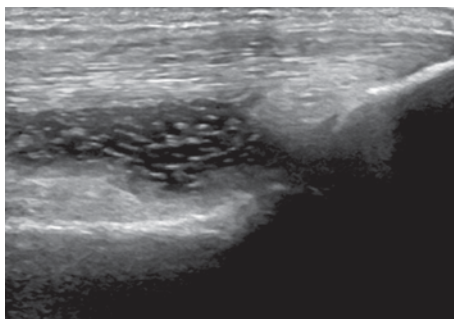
Ultrasound of the knee in OA. Evidence of osteophytes at the level of the lateral aspect of the joint. *OA* osteoarthritis
